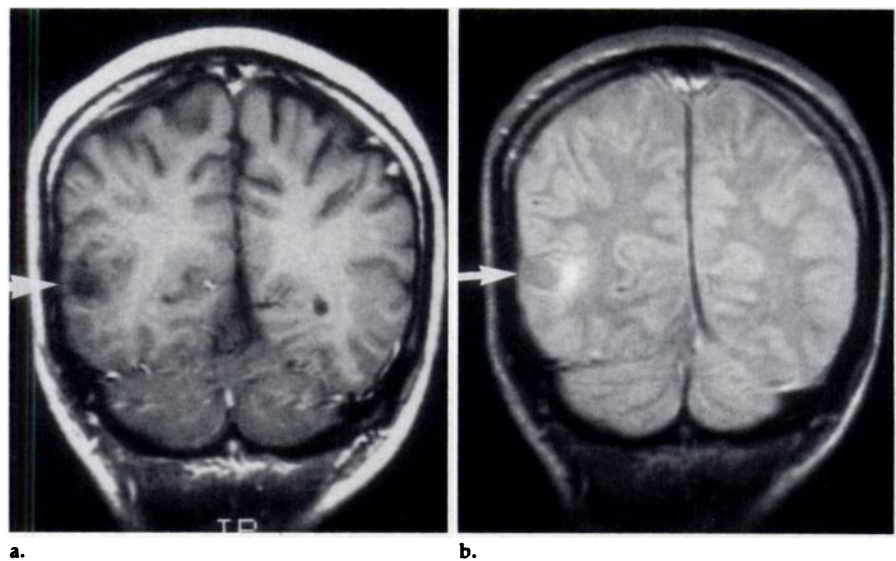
Cortical scar in a male patient who experienced complex partial seizures of right temporal origin due to a remote head injury. MR images demonstrate a focal cortical (arrow) abnormality, which was resected and shown to be a posttraumatic scar. (a) T1-weighted image and (b) first-echo image from a double-SE sequence demonstrate a small cystic area in the lateral right temporal neocortex with underlying signal intensity change, presumably gliosis.
